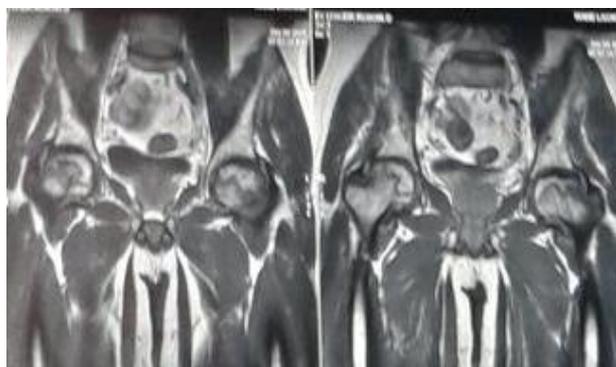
Coronal MRI of Pelvis with Both Hip
